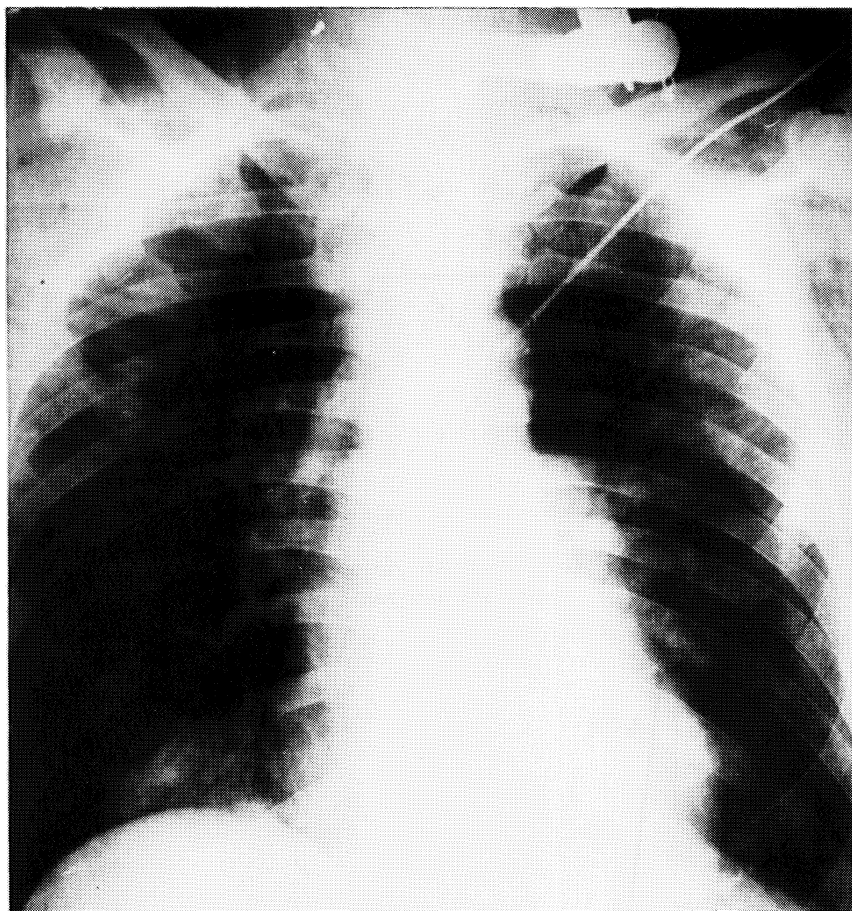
Chest x-ray of a 35-year-old man 10 h after blunt trauma of the thorax; artificial ventilation with an I/E ratio of 1:2.
